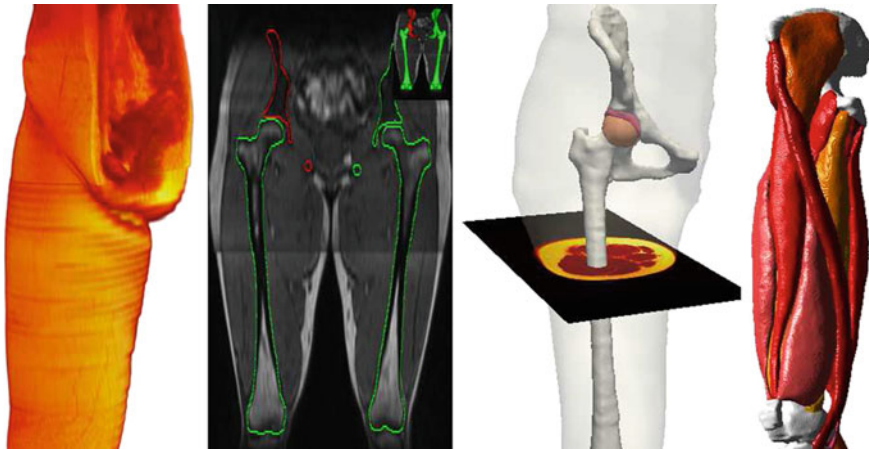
MRI dataset volume used to segment hip joint anatomical structures (*bones and cartilage*) and leg muscles
